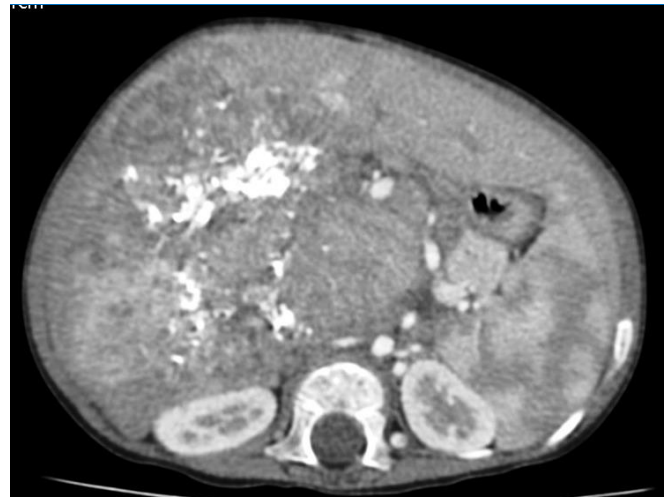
Axial Post Contrast CT abdomen shows enlarged liver with heterogeneously enhancing mass lesion. Non-enhancing necrotic areas are also seen within the lesion. The lesion abuts stomach & right kidney with preserved fat planes. The lesion displaces celiac trunk, main portal vein and left branch of portal vein to left side
